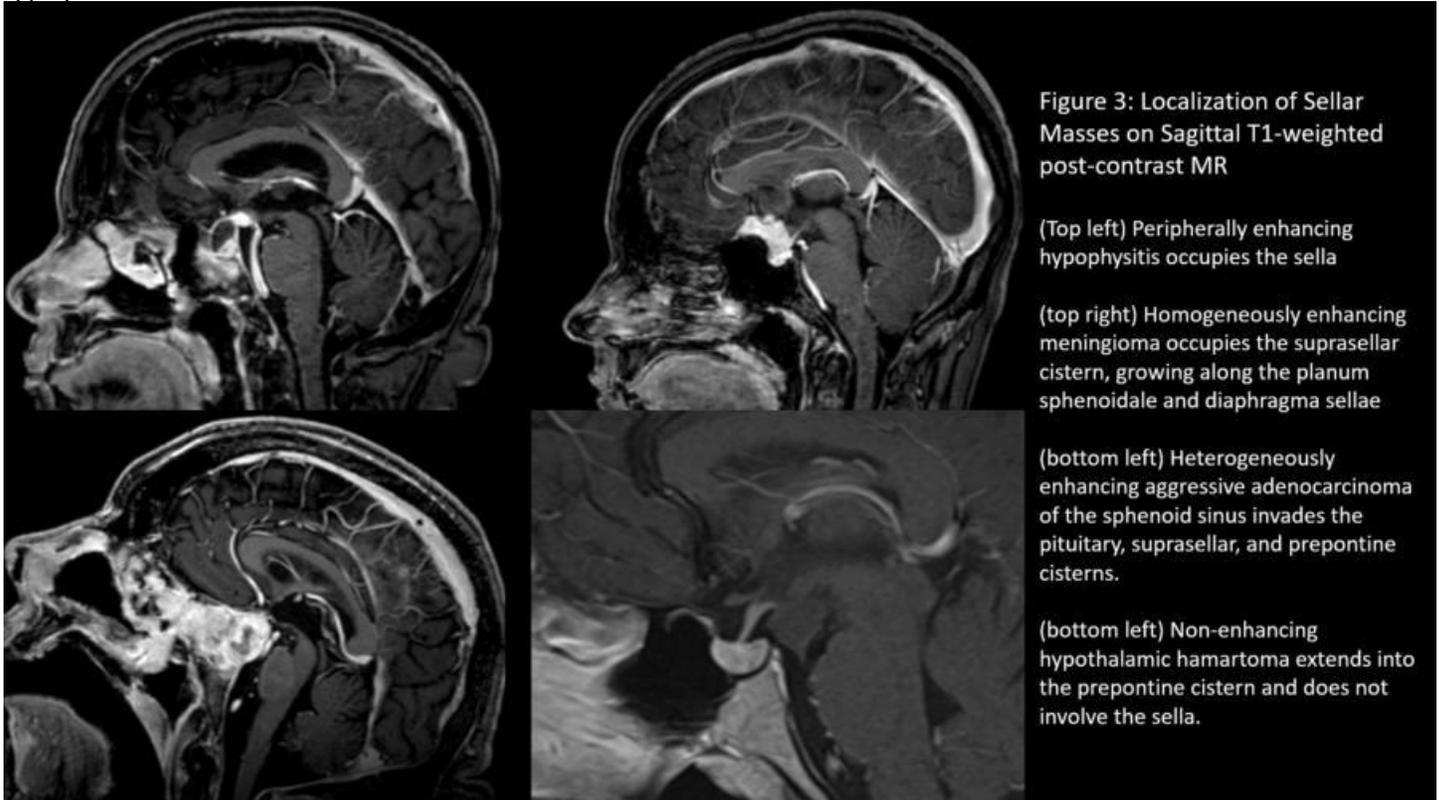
Localization of Sellar Masses on Sagittal T1-weighted post-contrast MR
